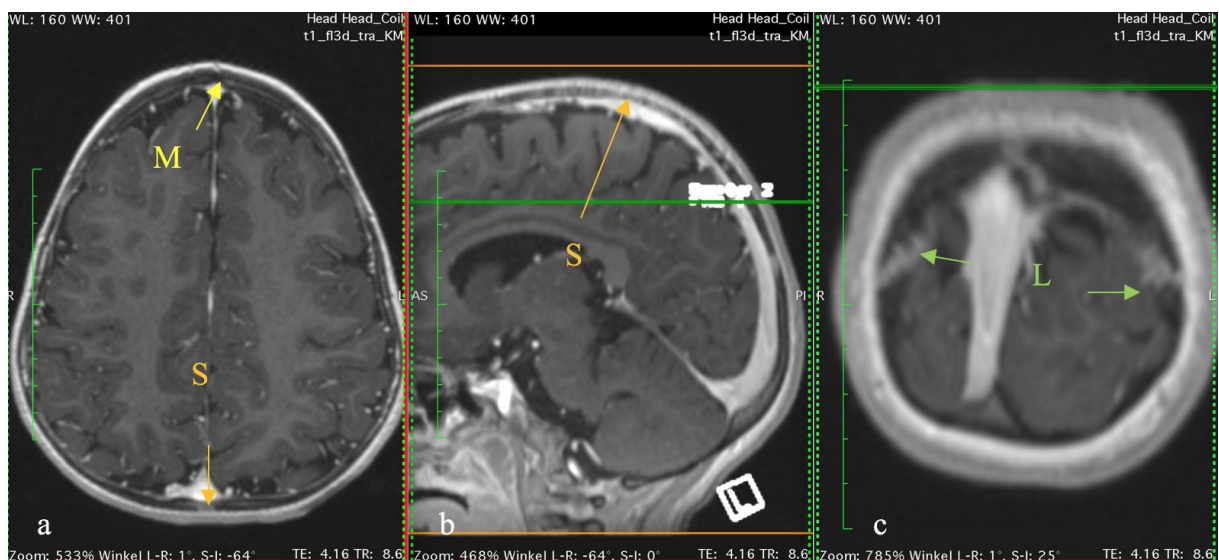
MRI of a pediatric skull of a 4 years old female showing assessed sutures of the skull cap in a axial view, b sagittal and c coronal reformat (yellow arrow: metopic suture, orange arrows: sagittal suture, green arrows: left and right lambdoid suture).
